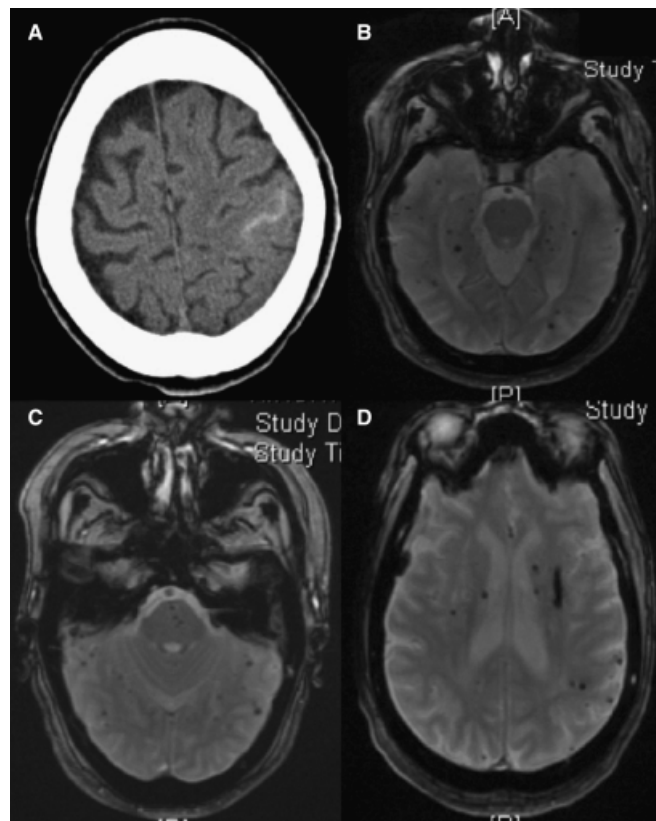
Computed tomography and magnetic resonance imaging of the brain. (A) Computed tomography scan demonstrating subarachnoid hemorrhage in the left postcentral sulcus. (B–D) Magnetic resonance image gradient-echo sequences revealing multiple foci of parenchymal microhemorrhage, as well as a slit-like lesion in the left putamen (D) corresponding to the patient's initial stroke.
